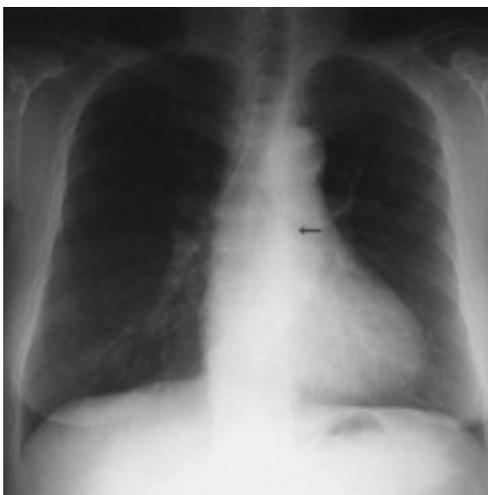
A chest X-ray showing a shell in the middle esophagus (indicated by the arrows).
